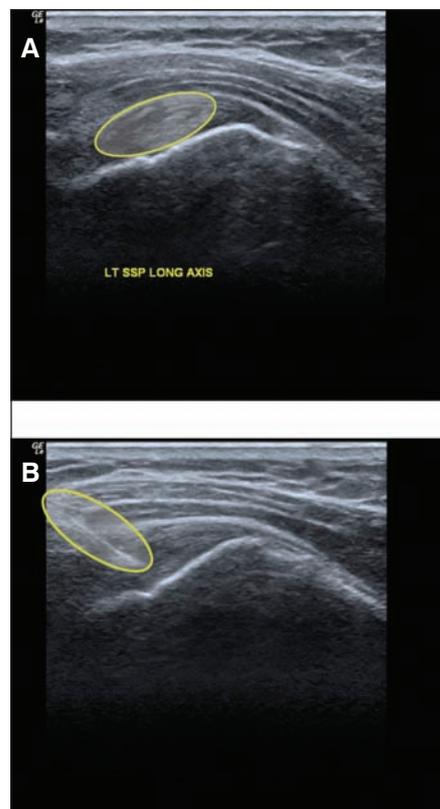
Supraspinatus injection.* A. longitudinal probe placement on the anterior/lateral shoulder reveals a nearly full thickness tear of the supraspinatus tendon. B. ultrasound guided injection.
